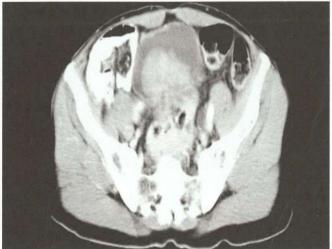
Contrast CT of the bladder showing filling defect suggestive of carcinoma bladder
